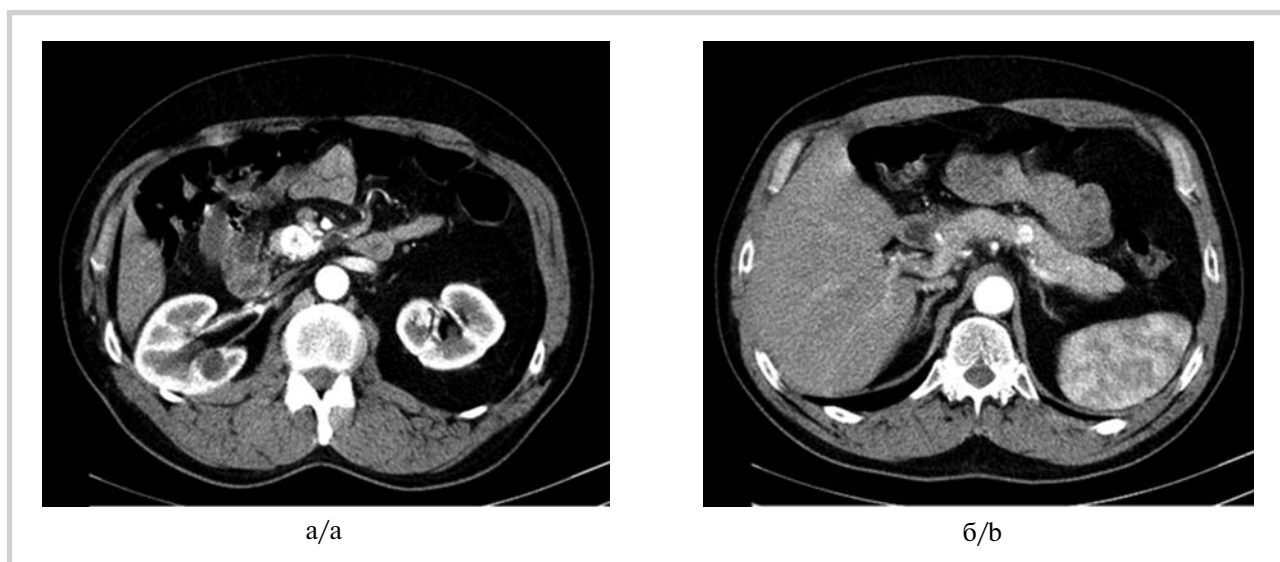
CT-scan, arterial phase, axial planes. Renal cell cancer metastases in the pancreas: metastasis in uncinus process (A) and pancreatic body.
